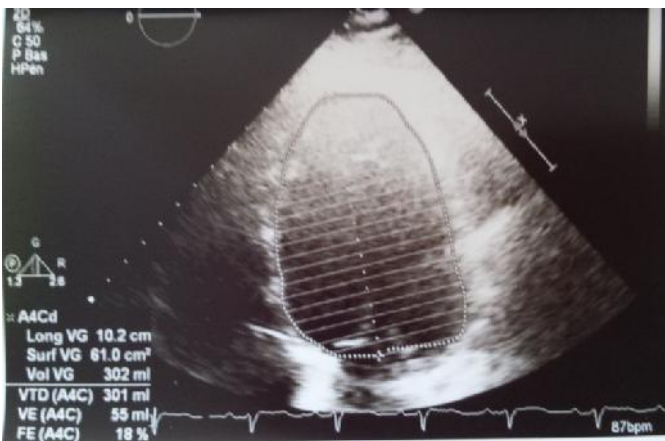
Echocardiography showing a dilated LV (4C)
